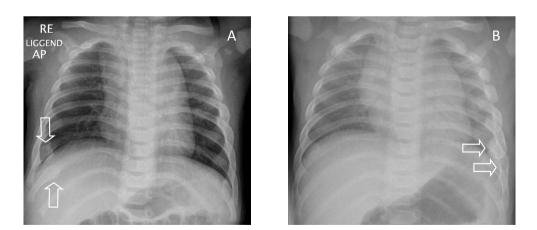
A 7-month-old child in whose twin rib fractures were seen on a chest radiograph (see Figure 1b). Based on that finding, a full skeletal survey was performed on this child and rib fractures (arrows) were found. Figure 1b. A 7-month-old child with persistent signs of pneumonia. On a chest radiograph, performed to rule out pneumonia, incidental rib fractures (arrows) were found.
